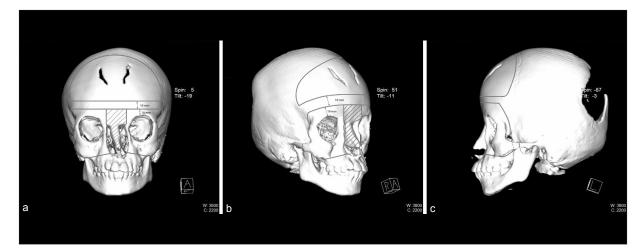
(a-c) 3D CT scan showing Tessier 2, 12 cleft and orbital hypertelorism with markings of the planned modified facial bipartition
